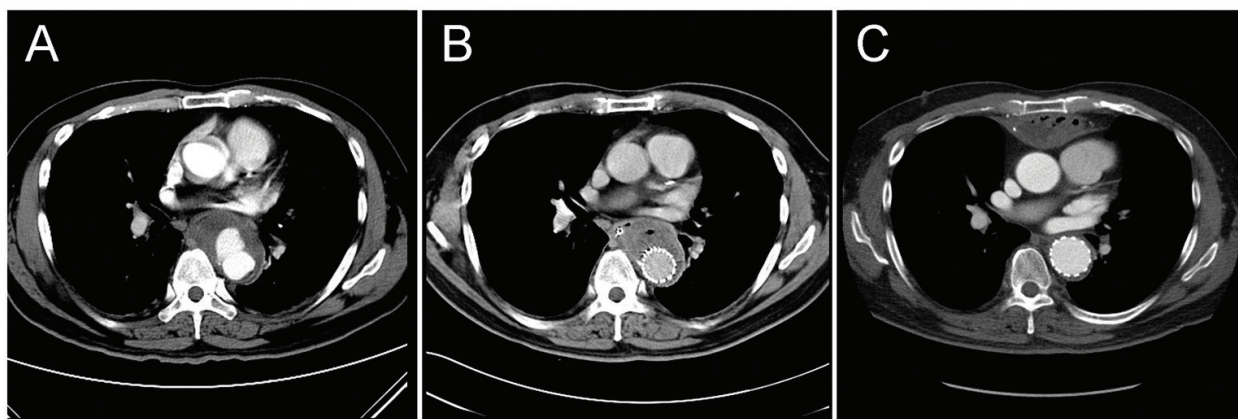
(A) Infected descending thoracic aortic aneurysm caused by *Salmonella enteritidis* in a 60-year-old male patient. (B) The patient was complicated with persistent local infection and esophageal perforation 1 week after TEVAR. Debridement and esophagectomy by a video-assisted thoracic surgery (VATS) was done. (C) Oral antibiotics were kept for 1 year after hospital discharge and CT angiography 3 years after TEVAR showed completely resolved periaortic infection. Note the retrosternal gastric tube for esophagus reconstruction.
